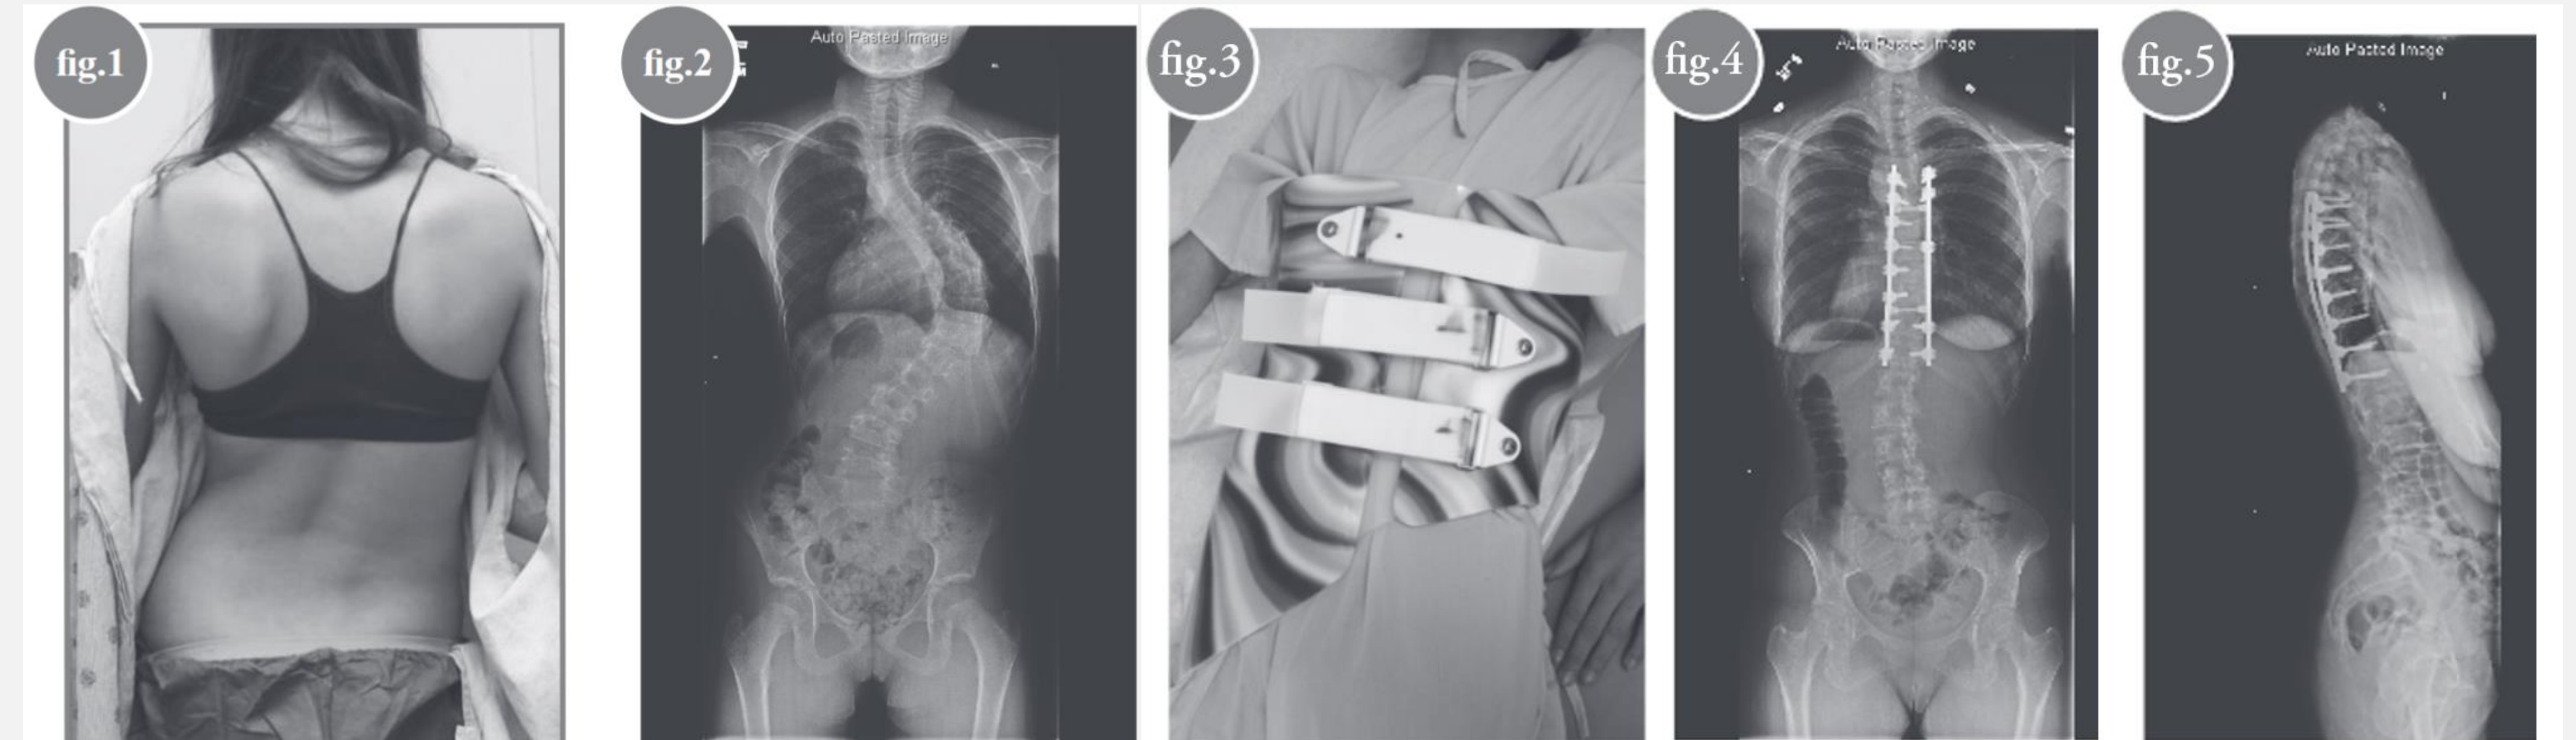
clinical presentation of scoliosis – spine curved like an “S” or “C”<sup>1</sup> Fig 3. Providence Nighttime brace<sup>1</sup> Fig. 4 & 5: X-Ray following posterior spinal fusion surgical treatment<sup>1</sup>
